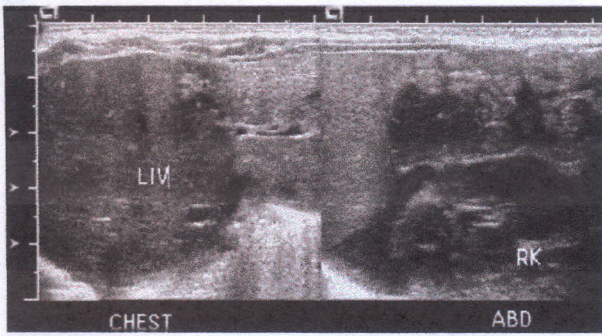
A 1-day-old boy with a Morgagni defect. Sagittal sonogram of the right chest shows herniation of the liver through an anterior foramen of Morgagni defect. Note the lower echogenicity of the herniated portion of liver (*LIV*). *RK* right kidney
